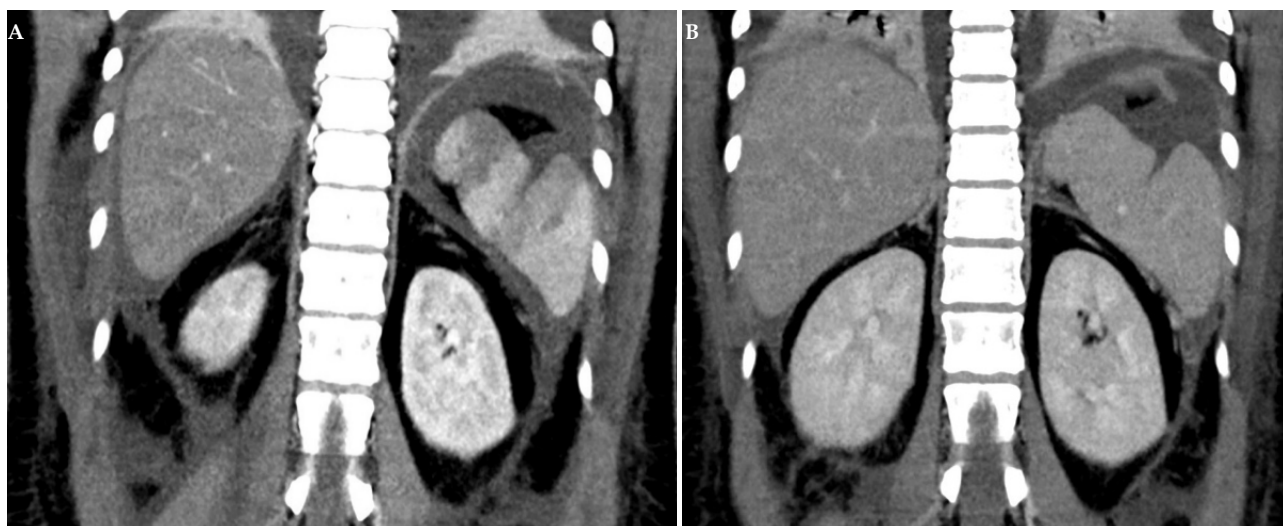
Coronal reformatted image of a contrast-enhanced CT scan of the abdomen. The hypoperfused areas in the spleen were improved on contrast-enhanced CT scan on day 8 (B) compared with those on admission (A).
